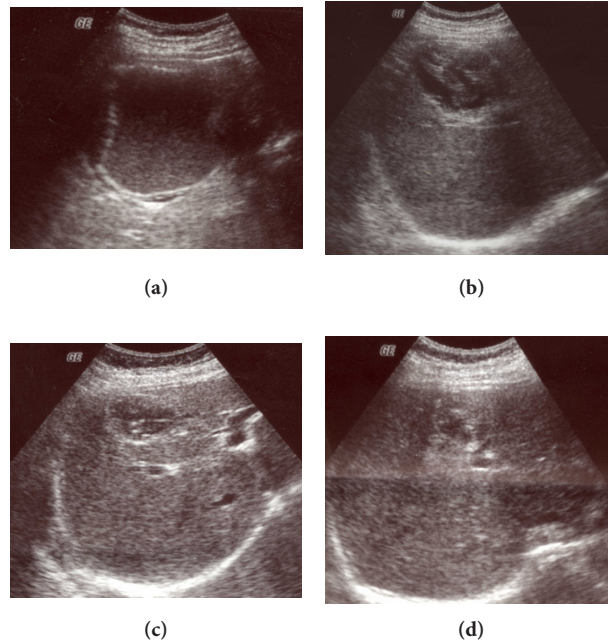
Type II hepatic hydrated cyst treated with PAI and sonographic follow up shows progressive decrease in the size and fluid content and remained unchanged after the first year. (a)Before aspiration. (b) three months after PAI, (c) after 1 year, (d) after 2 years.
